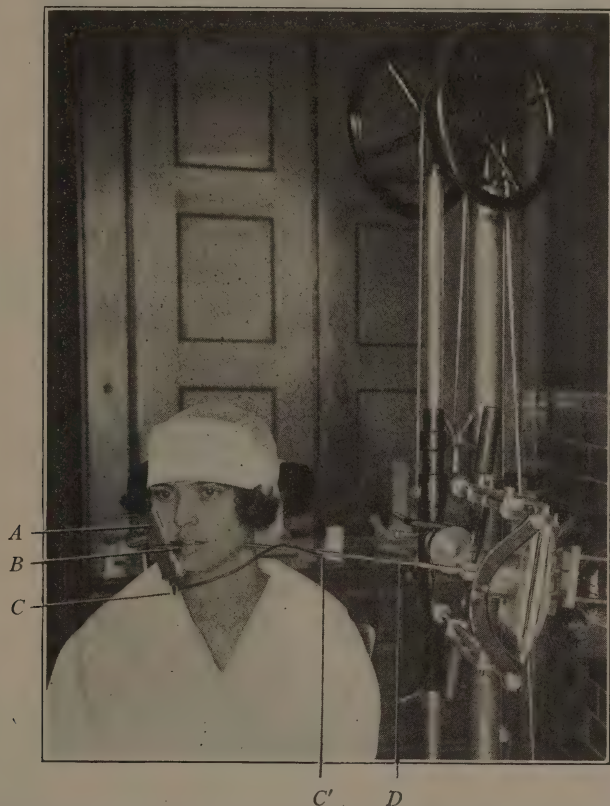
Posing the patient for an extra-oral picture (molar region) of the right side. (Bite guide shown in Fig. 495.) Cheek rests against the film holder *A*. *B* is the bite guide in the mouth. *C* and *C'*—the X-ray tube focussing guide. The tube is so adjusted that the dental pointer is exactly in line with the sliding rod *D*, and when that is done, it is in exactly the right position to focus the rays on the region set by the bite guide.
